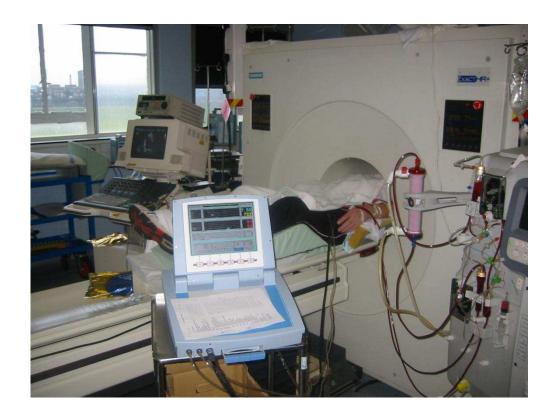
Patient connected to the haemodialysis machine being studied in the PET scanner. The Finometer and cardiac ultrasound scanner are also visible in this picture.
